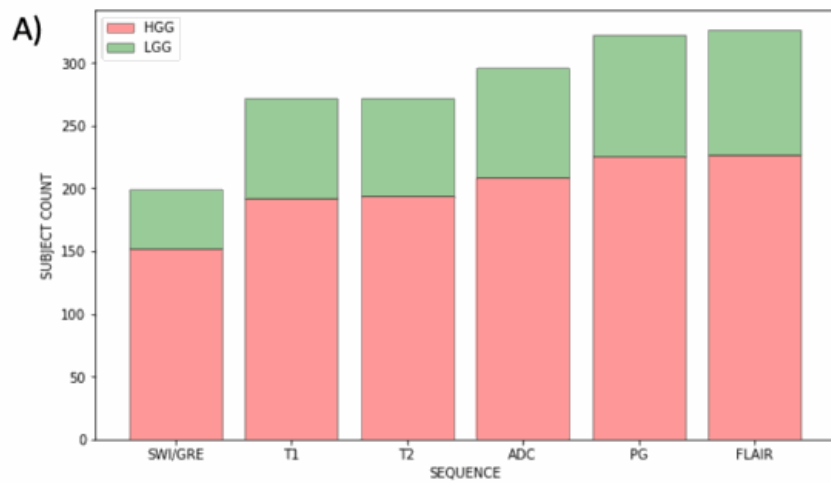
A) Number of subjects for each available sequence. HGG and LGG ratios are presented in pink and green colors (HGG=High-grade glioma; LGG= Low-grade glioma). B) AUC-ROC and Confidence Interval for different sequence and ROI combinations (ROI = Region of Interest). C) Example segmentation of whole tumor ROI on FLAIR sequence. D) Example segmentation of core and necrotic tumor ROIs on PGSE sequence.
